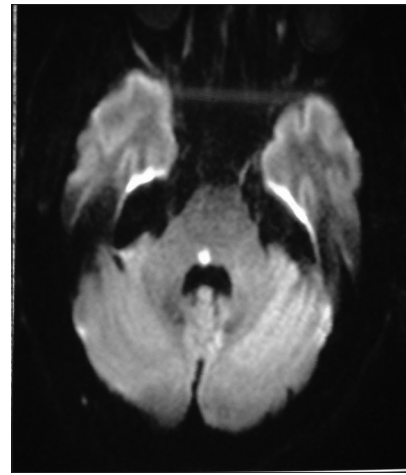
Magnetic resonance imaging brain: Diffusion-weighted images showing restricted diffusion suggesting acute infarct in the right medial pons
